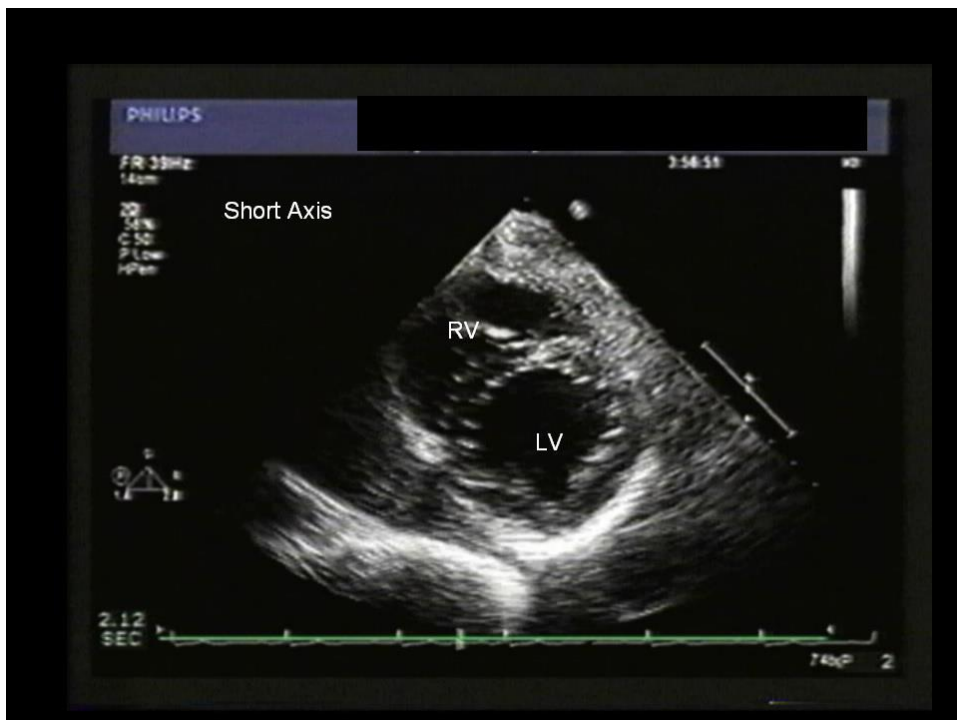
Parasternal short axis with view of the mitral valve. RV, right ventricle; LV, left ventricle.
